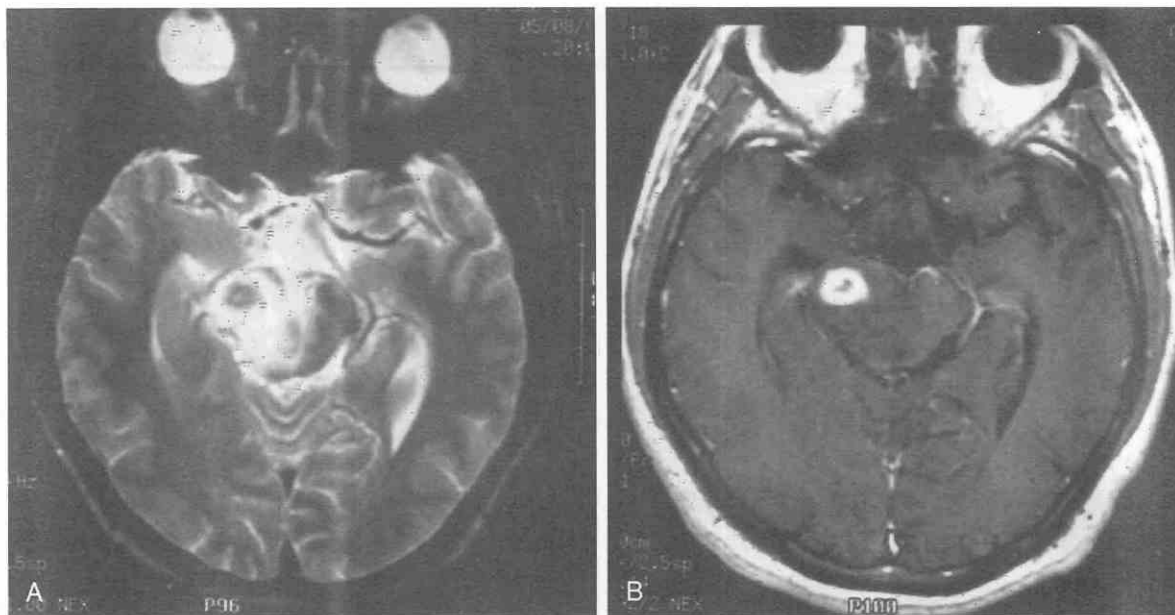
Toxoplasmosis. A, T2-weighted image shows a low-signal-intensity lesion in the right cerebral peduncle with surrounding edema. B, Gadolinium-enhanced MRI study shows a ringlike enhancing lesion in the right side of the midbrain.
